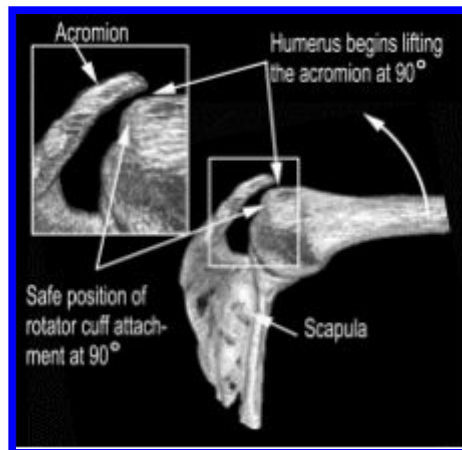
A CT scan image of the left shoulder of a live subject holding the arm at 90 degrees elevation. This CT study was made for the sole purpose of demonstrating the safe position of the rotator cuff with the arm elevated to the horizon. The view is from the side of the subject. Notice that the rotator cuff attachment area has already passed behind the acromion part of the CA arch that could cause pinching of the rotator cuff. When the arm is elevated a little higher, notice how the upper part of the humerus bone will come to a position to contact and lift the acromion.
